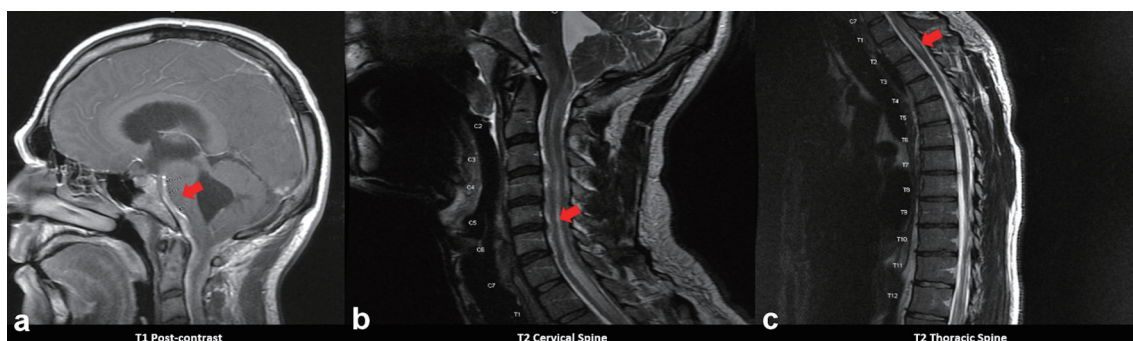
MRI brain with and without contrast showing (a) leptomeningeal enhancement most prominent along the ventral margin of the brainstem and perimesencephalic cisterns, indicated by the red arrow. Images (b) and (c) depict hyperintensity along the cervical and thoracic spine, indicated by red arrows (case 2). MRI: magnetic resonance imaging.
